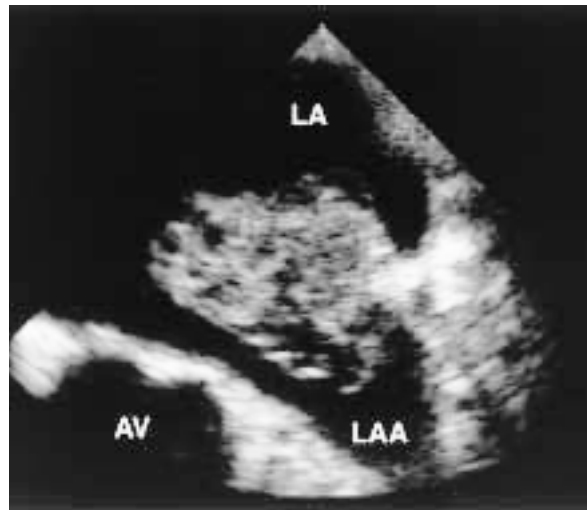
Transesophageal echocardiogram (left atrial appendage view)
